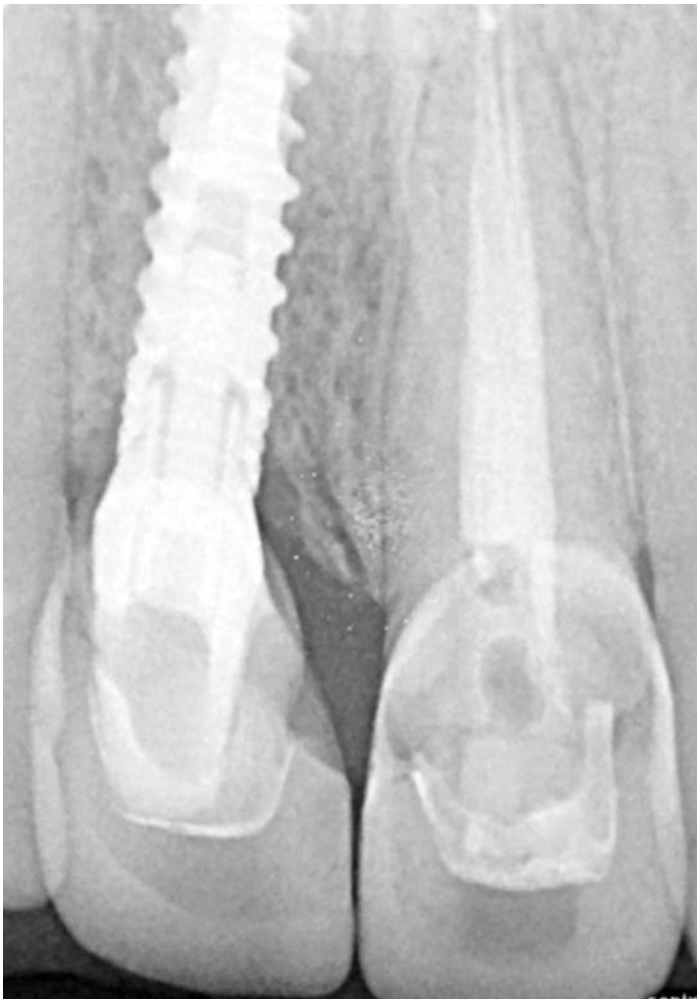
Postoperative radiograph showing perfect fit of the restorations with no excess cement.
